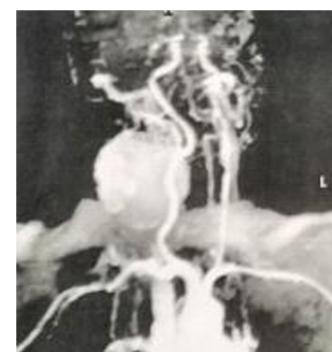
MRI shows a heterogeneously enhancing large lesion with, while achieving an aspect of pseudoaneurysm.
